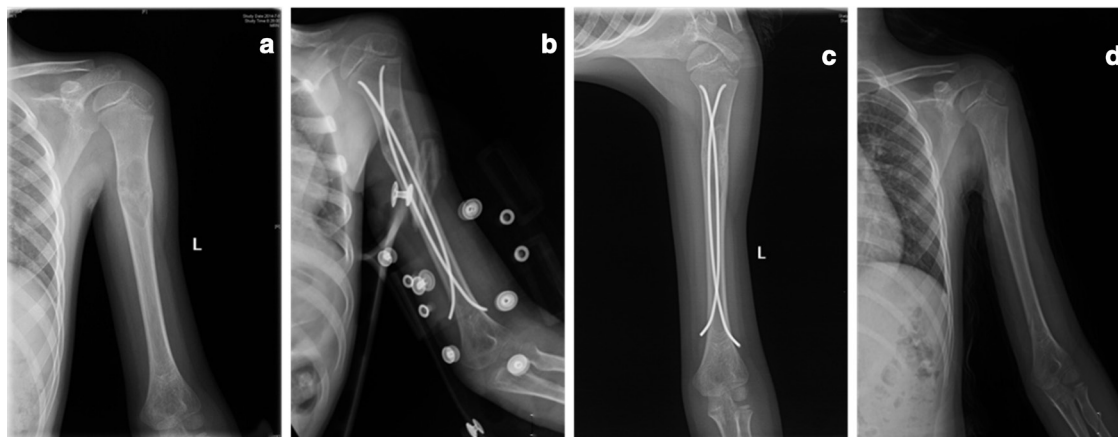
Male aged eight years and three months, unicameral bone cyst at left humerus proximal, one injection, healed (Capanna grade I). Elastic intramedullary nails removed seven months after surgery: a) radiograph of left humerus preoperative; b) radiograph after one day; c) radiograph after four months; d) radiograph after eight months.
